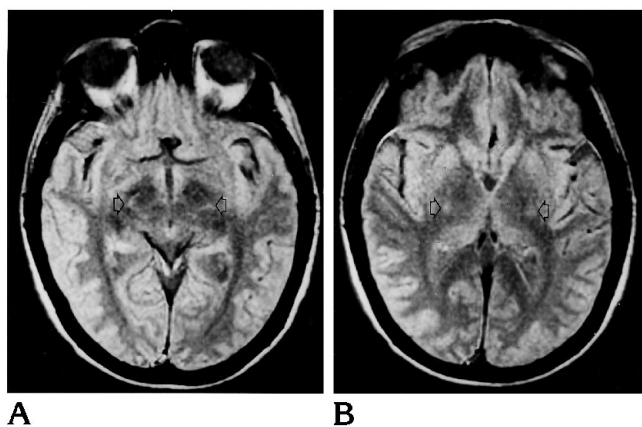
Case 2 (amyotrophic lateral sclerosis). Axial proton density-weighted spin-echo MR images (2240/40/2) show symmetric circumscribed hyperintensity (arrows) in the cerebral peduncle (A) and in the internal capsule (B).
